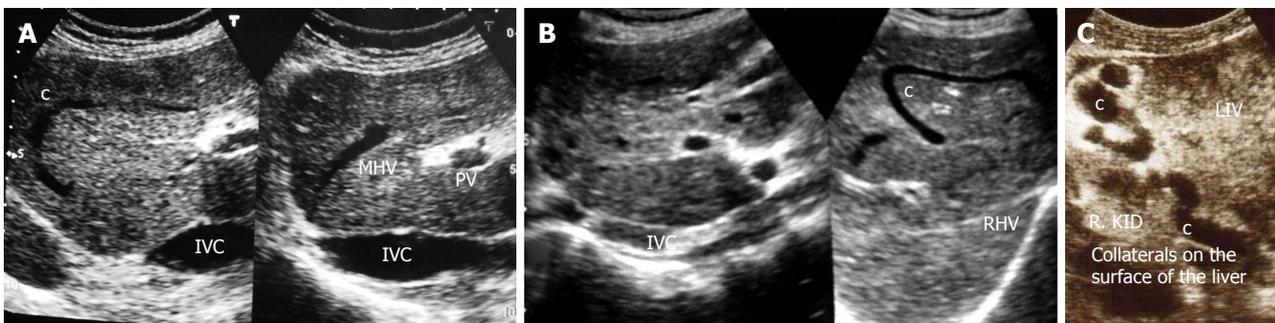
Ultrasonography showing collaterals. A: Ultrasonography of a patient with liver cirrhosis due to complete inferior vena cava (IVC) obstruction at cavo-atrial junction showing obstruction of middle hepatic vein (MHV) and an intra-hepatic collateral (c); B: Ultrasonography of a young girl with liver cirrhosis: IVC is filled with old organized thrombi of different ages, right hepatic vein (RHV) is thrombosed and a large intra-hepatic collateral is seen; C: Ultrasonography showing dilated collaterals on the surface of liver (LIV) close to right kidney (R. KID) in a patient with liver cirrhosis. PV: Portal vein.
